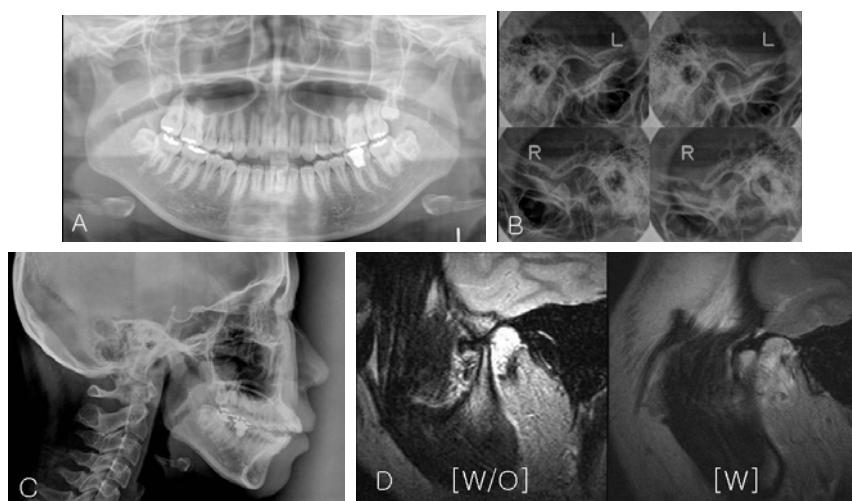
A, Panoramic radiograph with condylar resorption; B, lateral transcranial radiograph; C, Lateral cephalometric radiograph; D, sagittal views of MRI on opening, ADD W/O R (anterior disc dislocation without reduction) and ADD W R (anterior disc dislocation with reduction) with condylar resorption
